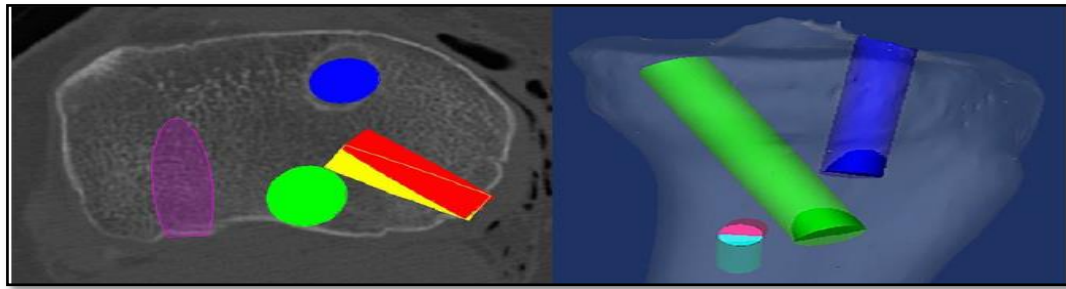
A CT of a right proximal tibia demonstrating different reconstruction tunnels. POL tunnel towards Gerdy's tubercle (yellow) increases the convergence risk with PCL tunnel (green). POL tunnel to a point 15 mm medial to Gerdy's tubercle (red) the convergence risk with PCL tunnel (green) can be reduced. sMCL tunnel 30° distally (light blue), the risk of convergence with PCL tunnel can be reduced [25].
